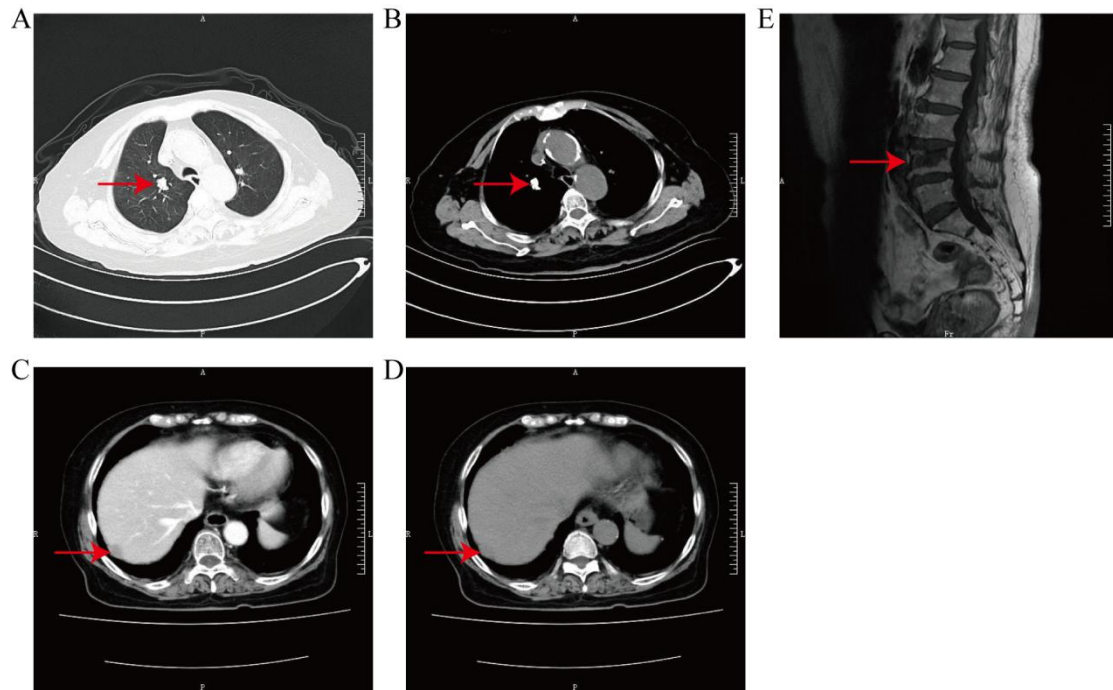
Radiographic data from case 3 - Computed tomography (CT) and magnetic resonance imaging (MRI) images. These radiographic data demonstrate that metastasis occurred in the liver, lung, and bone. (A) CT image in lung window. Metastasis can be observed in the lung (arrow). (B) CT image in the mediastinal window. Metastasis can be observed in the lung (arrow). (C) Cross-sectional contrast-enhanced arterial phase CT of the abdomen. Metastasis can be observed in the liver (arrow). (D) Cross-sectional contrast-enhanced venous phase CT of the abdomen. Metastasis can be observed in the liver (arrow). (E) Sagittal images of MRI. Metastasis can be observed in vertebrae (arrow).
